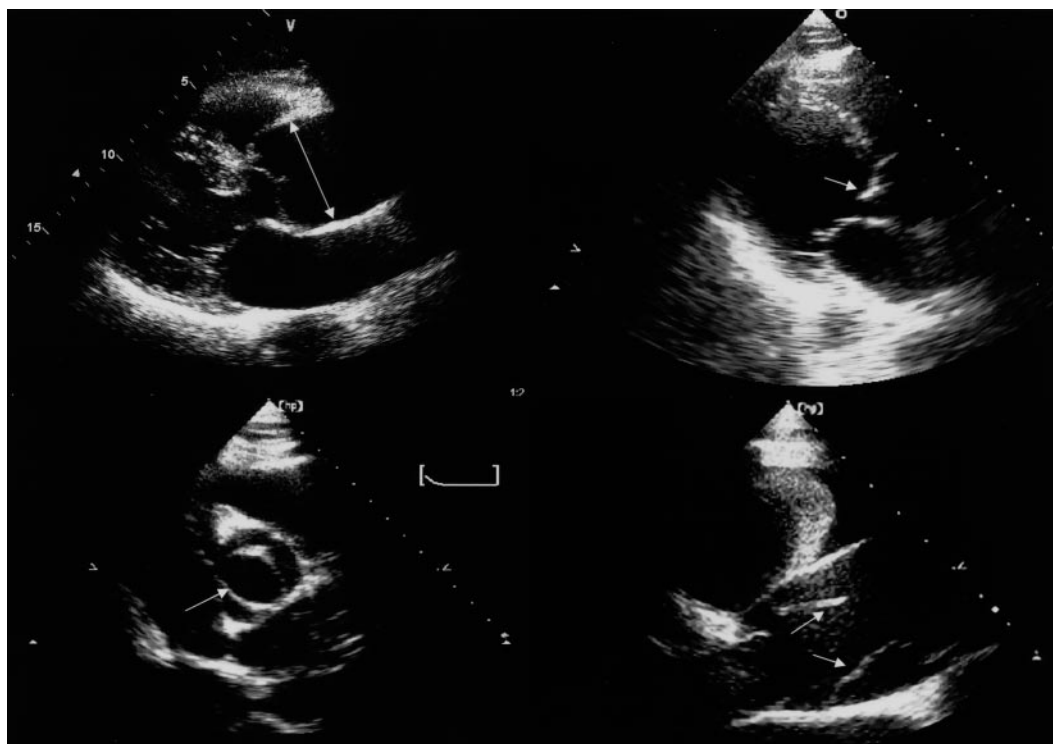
Echocardiographic images from different patients with AR due to different pathologies. Top left, Parasternal long-axis view showing a dilated aortic root (arrows) due to aortoannular ectasia. Top right, Parasternal long-axis view showing large, mobile vegetation (arrow) on the aortic valve in a patient with infective endocarditis. Bottom left, Parasternal short-axis view showing a bicuspid aortic valve with characteristic elliptical opening (arrow). Bottom right, Parasternal long-axis view of a patient with acute AR due to aortic dissection. Intimal flap is shown by arrows.
